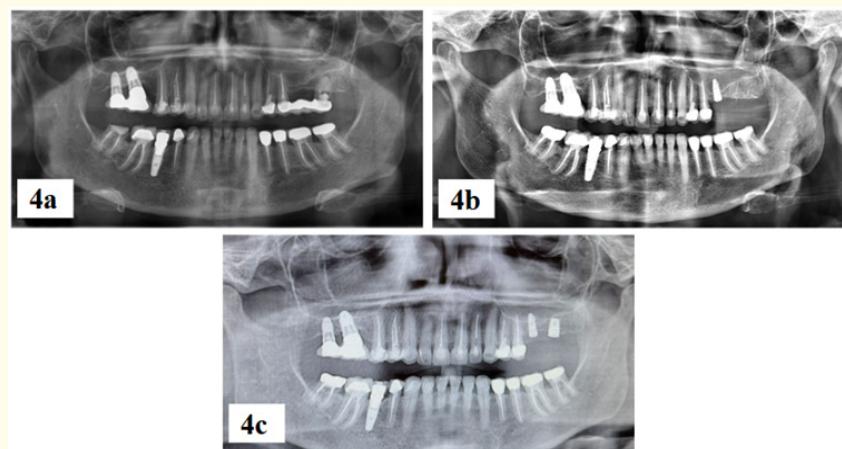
4a. Preoperative panoramic radiograph showing the edentulous #26 and #27 regions with reduced vertical bone height in #26. 4b. Immediate postoperative panoramic radiograph following sinus lifting and bone grafting in tooth #26 region. The dome-shaped appearance of the substitute bone around the implant is visible indicating proper sinus floor elevation. PRF was used under the implant to enhance bone healing following sinus floor elevation. 4c. Postoperative panoramic radiograph taken after 9 months demonstrating the successfully placed implants, showing increased bone height in the #26 regions.
